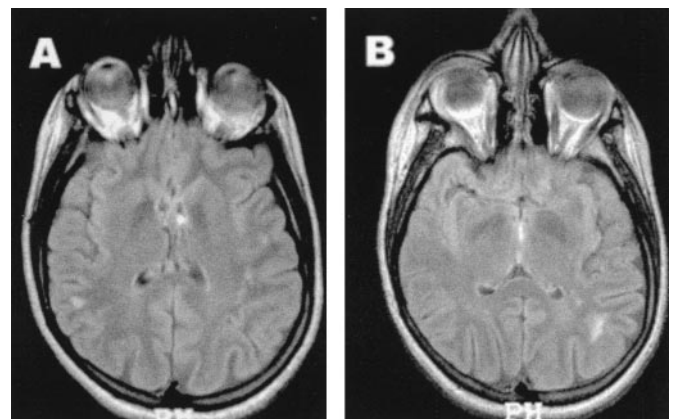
Axial T1-weighted and T2-weighted images showing diffuse cerebral atrophy and multiple small periventricular lesions in a patient with systemic lupus erythematosus and recurrent epileptic seizures.
